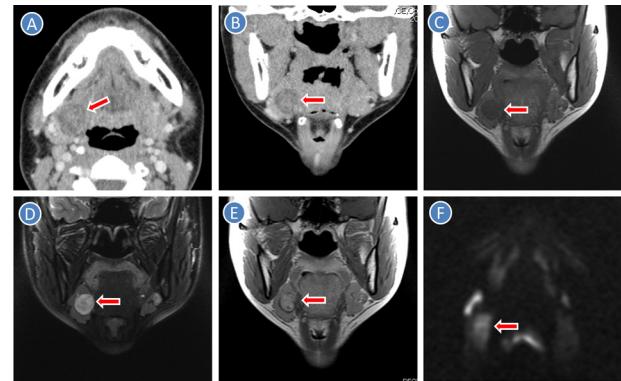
A Contrast-enhanced CT (Axial image), B: Contrast-enhanced CT (Coronal image), C: MRI (T1-weighted image), D: MRI (Fat-suppressed T2-weighted image), E: MRI (Contrast-enhanced T1-weighted image), F: MRI (Diffusion-weighted image). Arrow indicates tumor.
